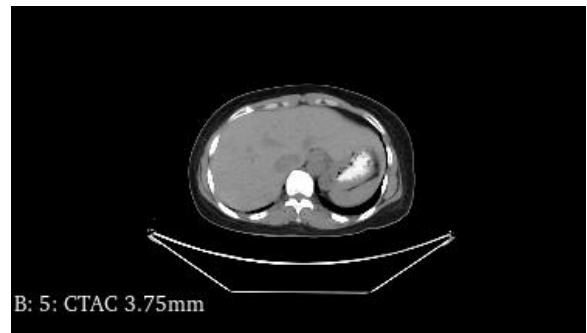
A slice of a CT image with HU values varying from low to high clearly shows the biological structure of each pixel.
